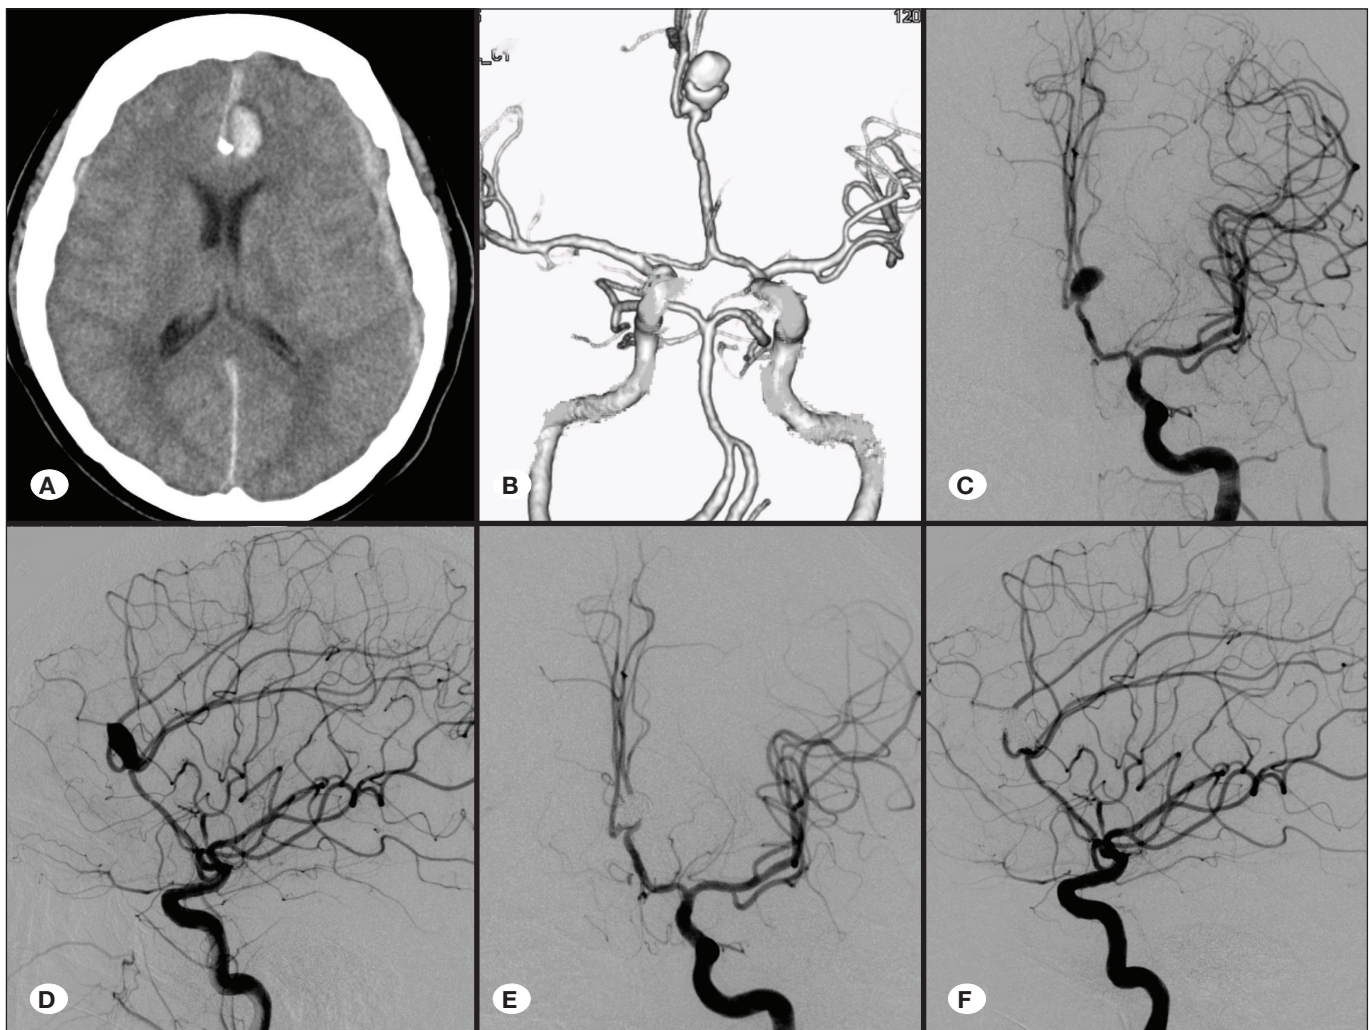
A) Plain computed tomography (CT) of the brain revealed a subarachnoid hemorrhage in the interhemispheric fissure with a left frontal hematoma. B) CT angiogram of the brain revealed giant, saccular aneurysm at the genu of the corpus callosum. C,D) Left internal carotid (ICA) angiograms, anteroposterior view (C), and lateral view (D) showed the azygos anterior cerebral artery (ACA) and saccular aneurysm at the A2-A3 junction. E,F) Left ICA angiograms, anteroposterior view (E), and lateral view (F) after coil embolization showed complete occlusion of the aneurysm.
